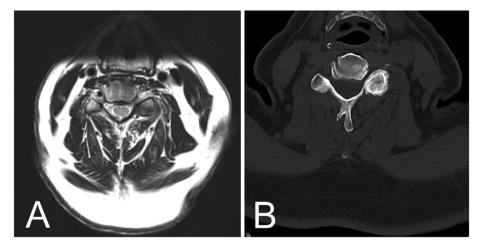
A. Axial CT and B. T2-weighted MRI of the cervical spine revealed adjacent segment disease at C4-5. Compression of the exiting C5 nerve root on the right is noted with disk herniation and boney overgrowth into the foramen.
